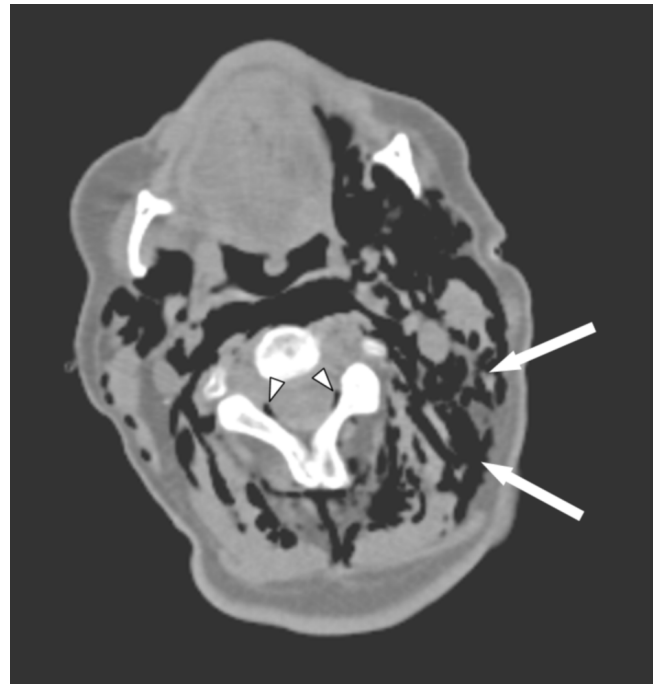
80-year-old man with massive subcutaneous emphysema. Axial CT at the level of the neck shows extensive subcutaneous emphysema (arrows) and pneumorrhachis (arrowheads).
